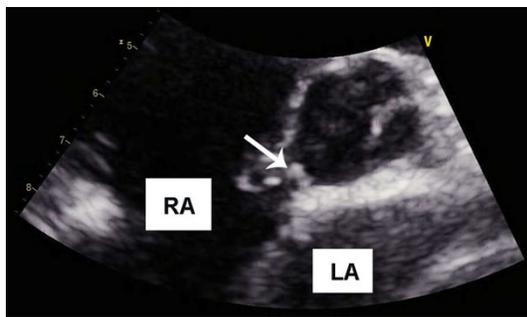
Preoperative transthoracic echocardiography: congenital heart disease-ruptured NCSVA into the right atrium (arrows); LA: left atrium; RA: right atrium.
